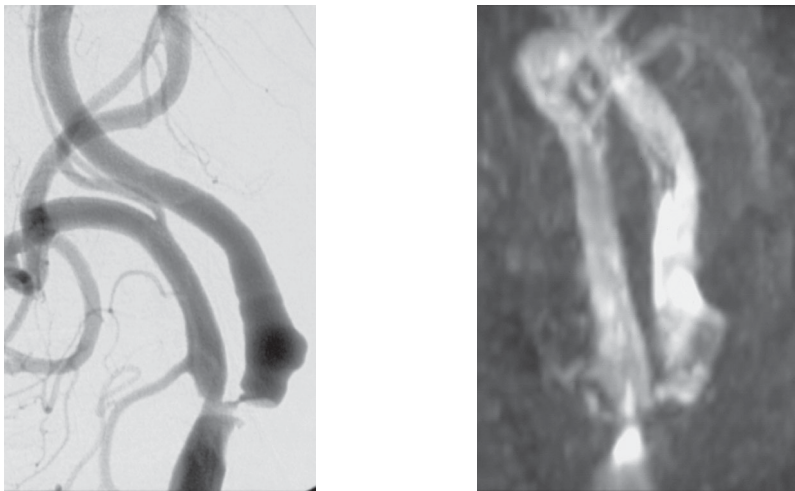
Male (age 74): Digital subtraction angiography on the left (DSA) and time-of-flight magnetic resonance angiography on the right (MRA) both show a severe stenosis (70-99%) in the internal carotid artery (ICA). The peak systolic velocity (PSV) at Duplex ultrasound (DUS) examination was 520 cm/sec
